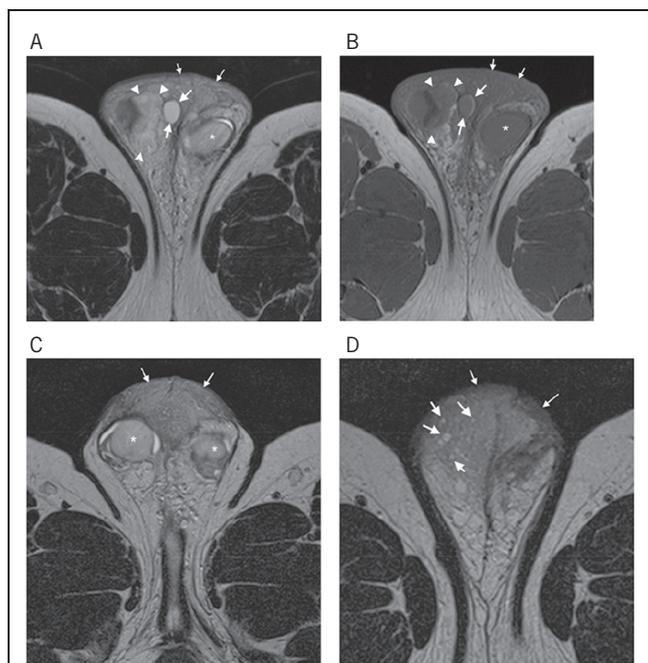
Case 4: T1 (A) and T2 (B) weighted spin echo axial magnetic resonance imaging at presentation, and T2 sequences at three months after presentation (C and D). Nodules of silicone are seen (large arrows), as are less well defined foci (arrowheads). Note that on the T2 sequences (and on short tau inversion recovery sequences [not pictured]), both the oedematous surrounding fat and the silicone, as well as the testes (asterisks), are of high signal, the silicone being most intense. On the T1 sequence, all of these components are of intermediate signal. However, a chemical shift artefact (seen best around the nodule indicated by the large arrows) is produced by the different resonant frequencies of the silicone and oedematous fat, resulting in an artefactually bright left border and dark right border to the silicone. At three months, most of the large lobules of silicone have been removed or have diffused but several small nodules are still visible (large arrows). Reactive oedema, thickening and induration (small arrows) remain in the scrotal skin.
